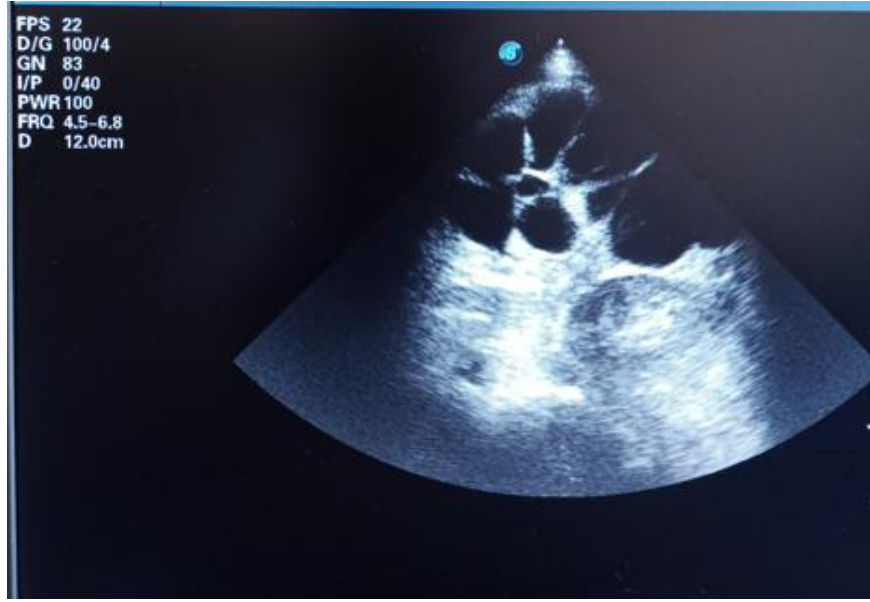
Abdominal Ultrasound showing a 8.6x7.4x4cm left intraperitoneal multiloculated cystic lesions which pushes the bowel wall posteriorly and has multiple septa having color flow & echodebris
